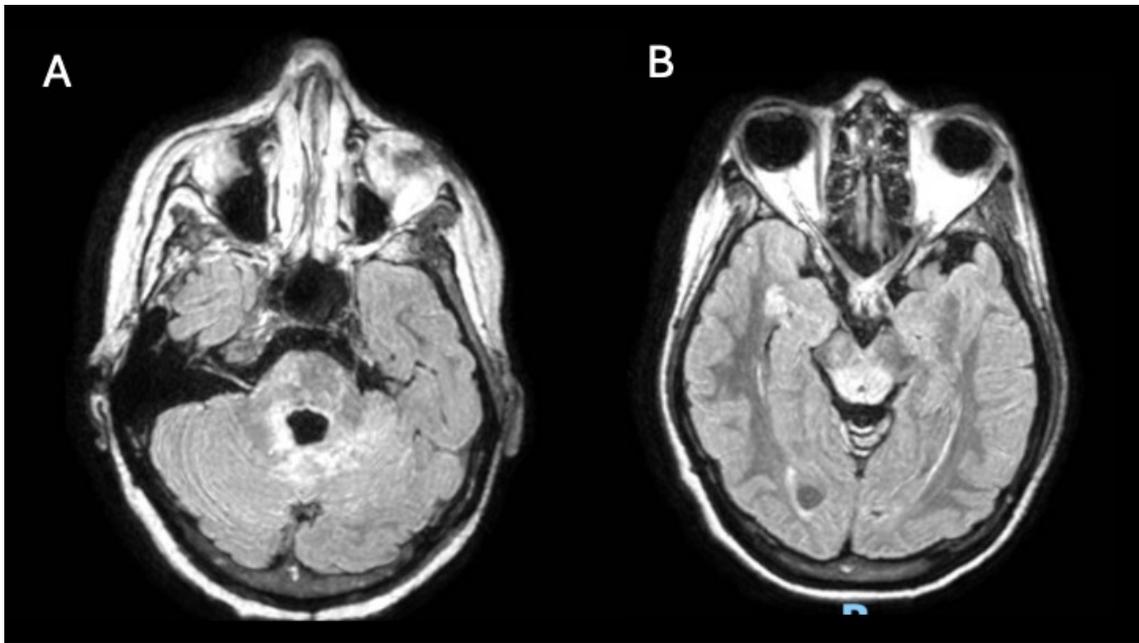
Imagem de RM de encéfalo em sequência FLAIR com cortes axiais demonstrando: A- Alteração de sinal em tronco encefálico Peri-quarto ventrículo. B- Alteração de sinal em tegmento mesencefálico e periaqueductal. Paciente 35 anos DENMO Anti-AQP4+.
